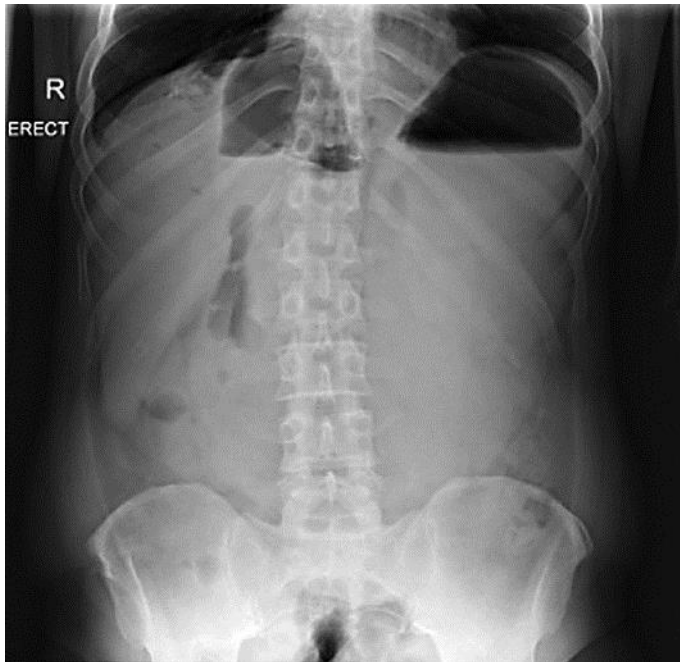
Abdominal X-ray showing air/fluid level, dilated stomach, and gas-filled bowel loop, above the line of the right hemidiaphragm.
